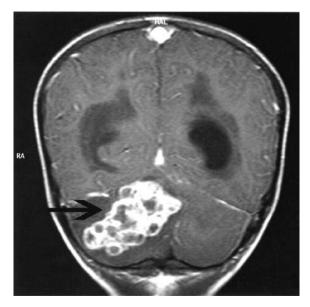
Cranial MR images before medical therapy. In the right cerebellar hemisphere and vermis, there are multiple millimetric conglomerated lesions (arrow).
